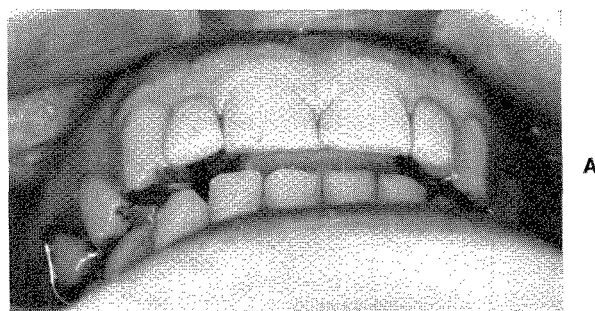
A, The new bite plate in position. The old one was lost. This is worn at night only. B, Roentgenograms of the teeth taken in 1962. These reveal normal structures in spite of the orthodontic treatment and the necessity of wearing a removable appliance. The patient was 46 years old.
